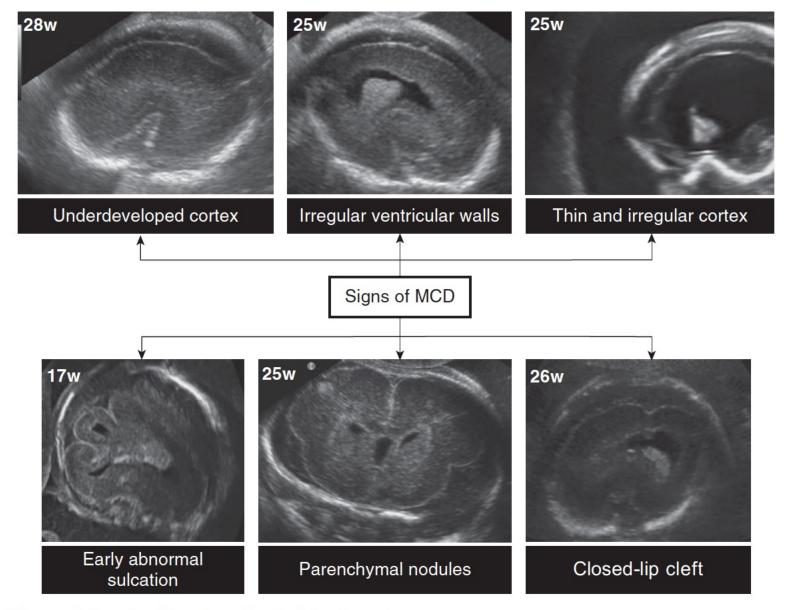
Ultrasound signs of malformations of cortical development.
